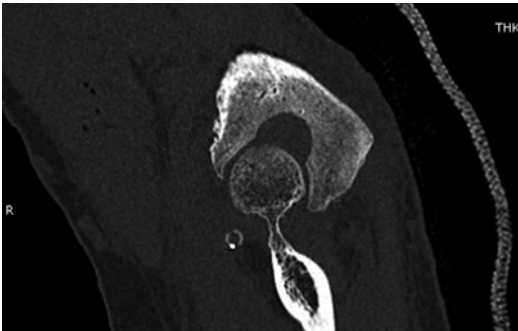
CT scan post osteoid osteoma resection
